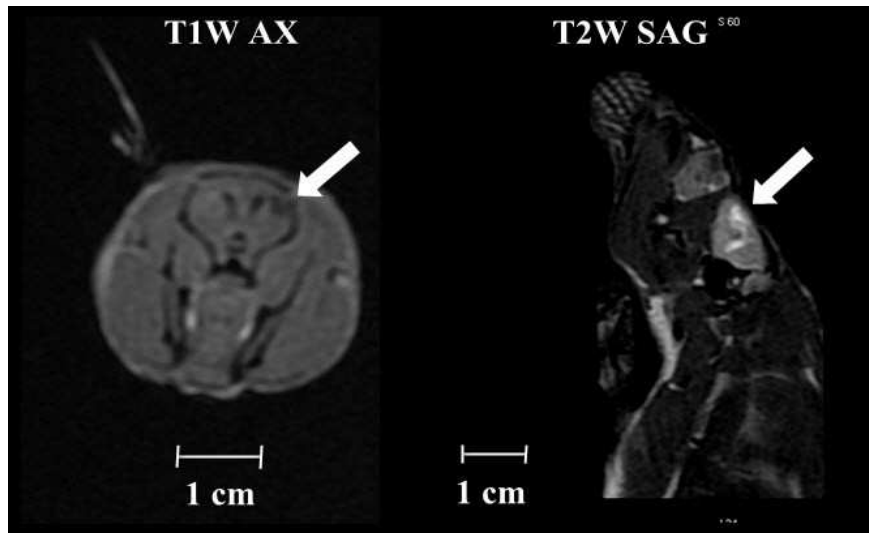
MRI revealed visible structural damage in the form of cavity formation in the cortical region, with extensive perifocal oedema, which appeared from 2 to 4 months following irradiation. Arrows show the site of the radiation injury. T1W AX: the T1-weighted image of the brain in the axial plane; T2W SAG: the T2-weighted image of the brain in the sagittal plane.*
